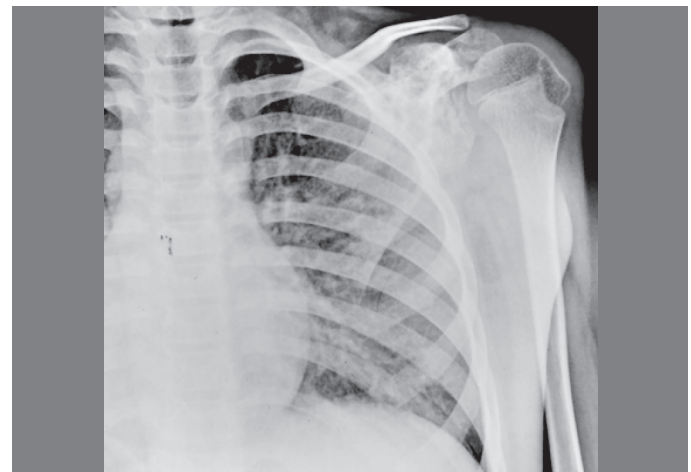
X-ray showing complete involvement of scapula neck and acromion..
